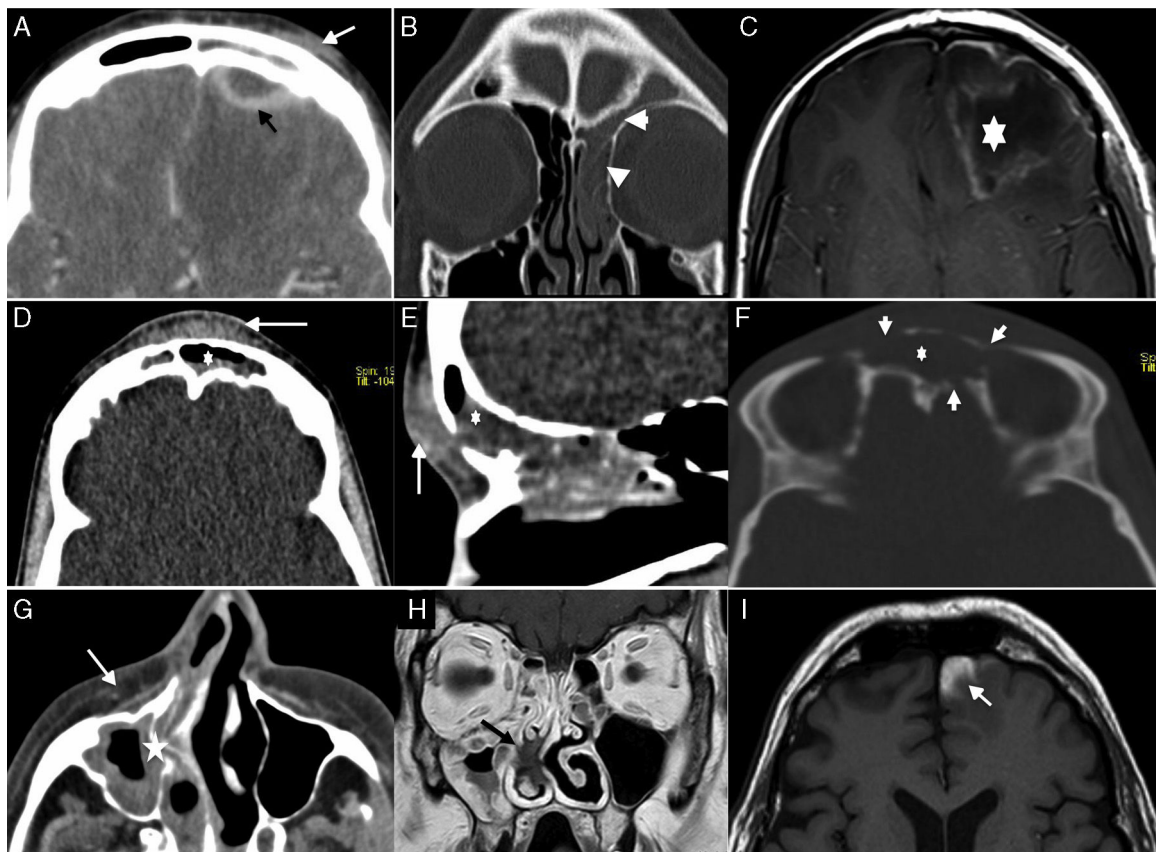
Complications of sinusitis. (A) Computed tomography (CT), axial section with IV contrast. (B) CT, coronal section. (C) T1-weighted axial MRI section with gadolinium. This is a patient who had showed up at admission 2 weeks before with periorbital edema diagnosed and treated outpatiently as preseptal cellulitis without performing any imaging modalities. She comes again due to an increase of periorbital edema and headache. CT is indicated (A, B) due to suspicion of retroseptal cellulitis. The patient had frontoethmoidal sinusitis (arrowheads in B) with periorbital edema (white arrow in A) and an empyema (black arrow in A) and an intraparenchymatous abscess (asterisk in C) at the intracranial level. (D) CT, axial section. (E) CT, sagittal section. (F) CT, axial section (window of bone). (D–F) This is a patient who after reporting symptoms of sinusitis the week before comes to the hospital due to frontal swelling. The existence of frontal sinusitis is confirmed (asterisk in D, E and F) with alteration and fragmentation of the frontal bone due to osteomyelitis (short arrows in F) and Puffy Pott's tumor (long arrows in D and E). (G) CT, axial section. (H) T1-weighted MRI coronal section with gadolinium. (I) T1-weighted MRI axial section. (G–I) Images of a patient under treatment for acute leukemia with pain and facial swelling. The first image showed right nasal-sinus occupation (star in G) with swelling of soft facial parts (arrows in G). The MRI with contrast showed normal nasal mucosa enhancement except for the area of the nasal crest where there was a lack of enhancement secondary to necrosis (equivalent to black-turbinate sign) (black arrow in H). Also there were areas of ischemia and hemorrhage in the frontal lobe parenchyma (white arrow in I). The patient died four days later due to a fulminating acute sinusitis secondary to *Aspergillus*.
